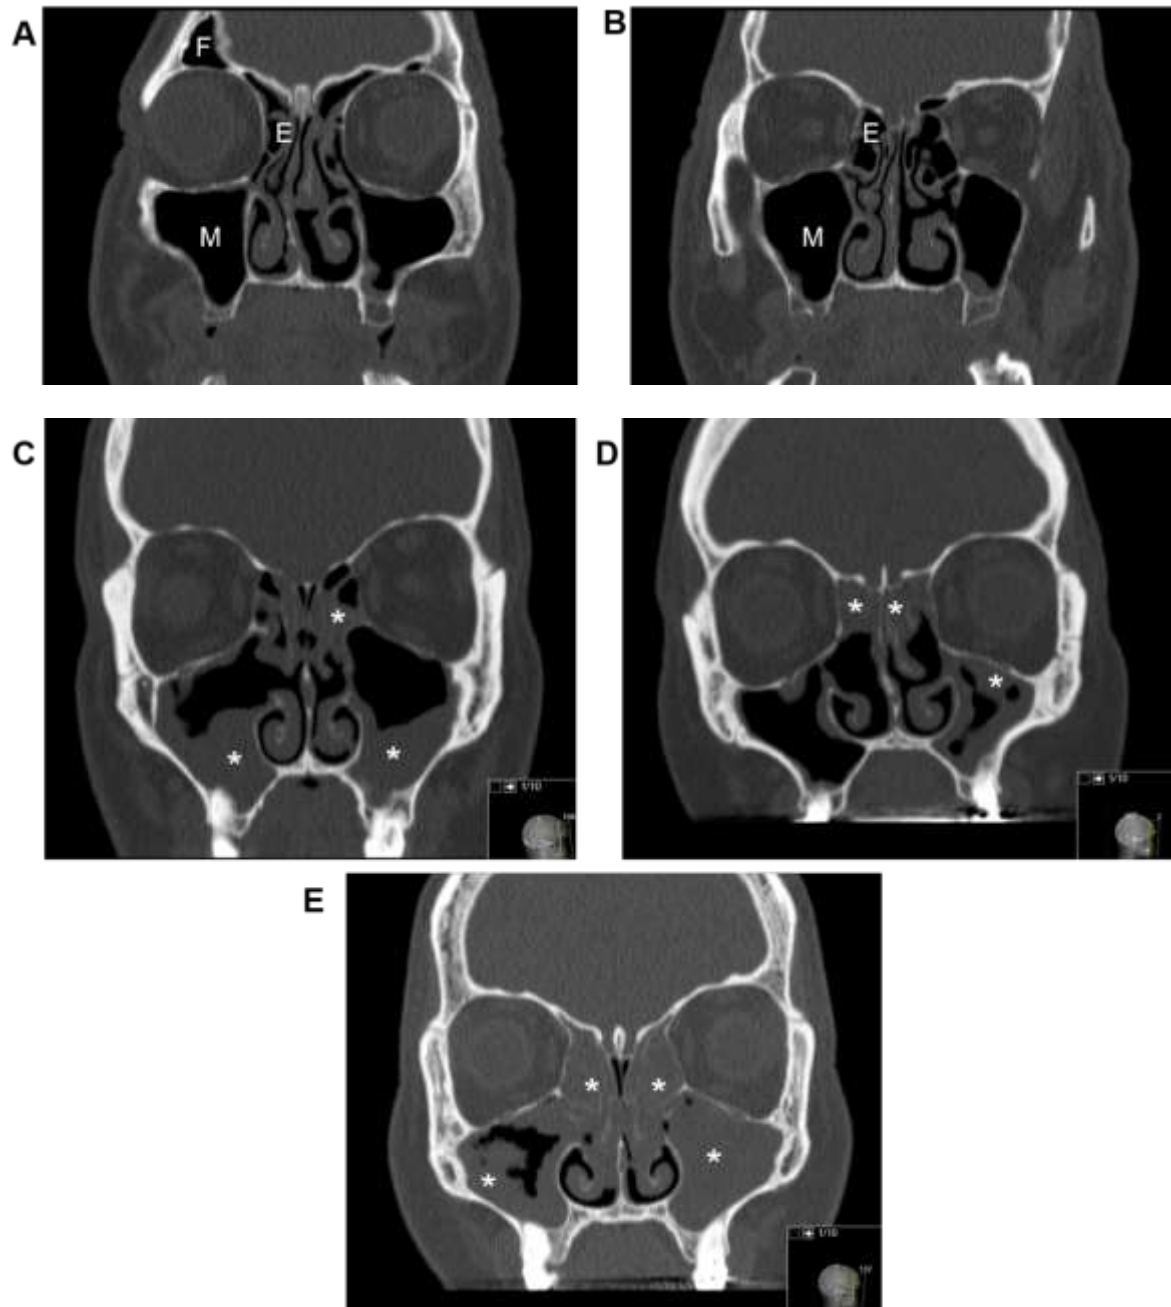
CT scan of the sinuses. (A-B) Healthy control and (C-E) three different CRSwNP patients. The patients display different grades of sinus obstruction and opacification, seen as grey instead of black color. F = frontal sinus, E = ethmoid sinus, M = maxillary sinus, * = partial or total opacification of the sinus.
